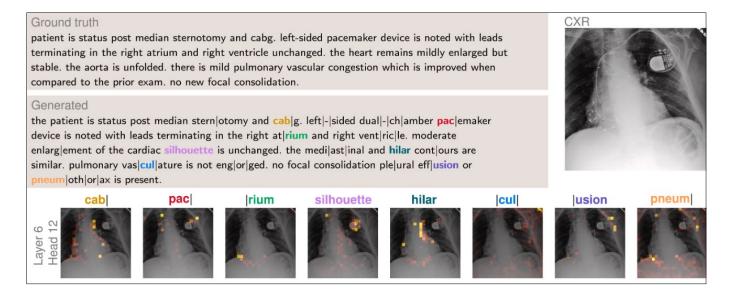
Case study of sample chest X-ray from the MIMIC-CXR test set. The 'ground-truth' report was produced by a radiologist, while the 'generated' report was produced by our model. The X-ray displayed has been pre-processed for testing. Subwords produced by our model (DistilGPT2) are separated by a vertical bar. Areas of attention from each word are highlight on the chest X-ray, providing explainable results for the clinician.
